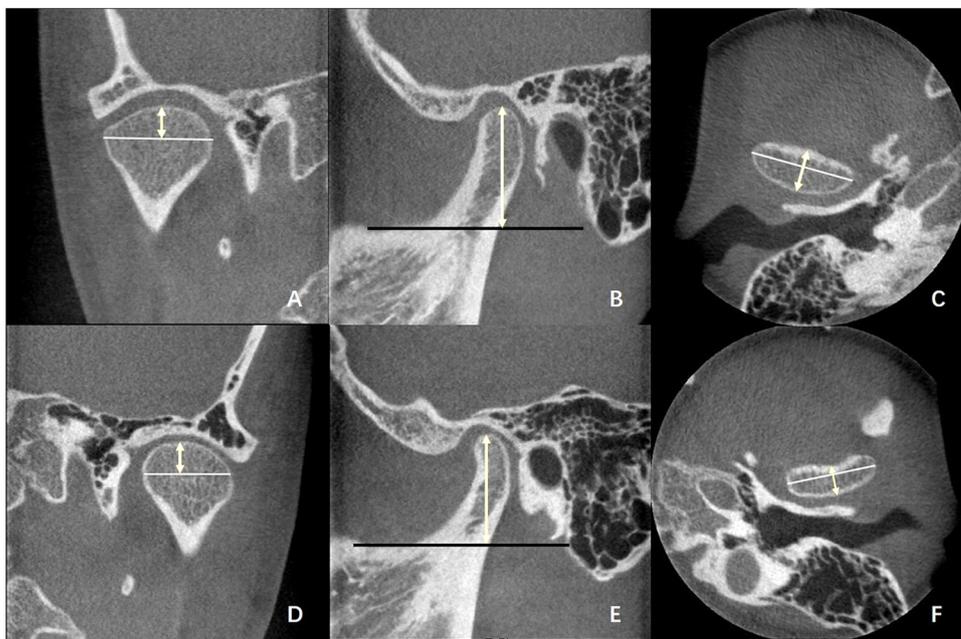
Bilateral temporomandibular joint cone beam computed tomography images of a patient with unilateral hypoplastic condyle (A–C: the contralateral side; D–F: the hypoplastic side). The white double arrows indicated the height of condylar head (A, D), the condylar length (B, E) and the condylar depth (C, F).
